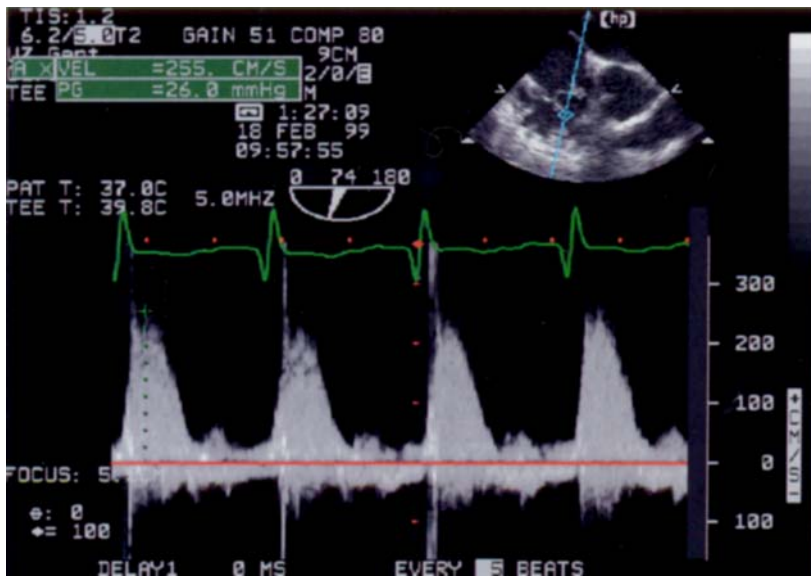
Continuous wave Doppler pattern across the tricuspid valve. Estimation or direct measurement of peak velocities allows calculation of right ventricular systolic pressure, utilising the modified Bernoulli equation.
